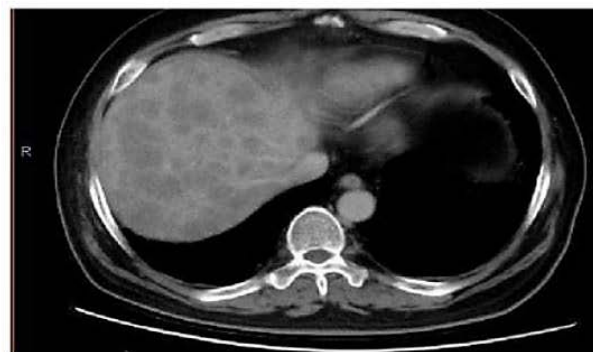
CT Images of Two Patients
